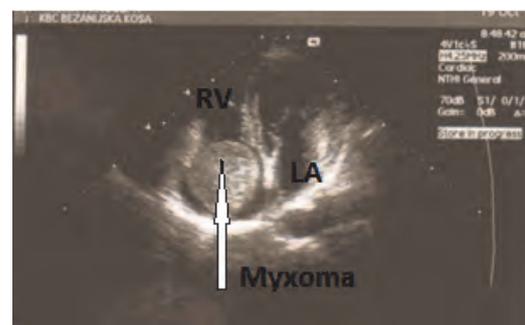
Echocardiogram shows the right atrial myxoma (highlighted). (LA – left atrium, RV – right ventricle).
